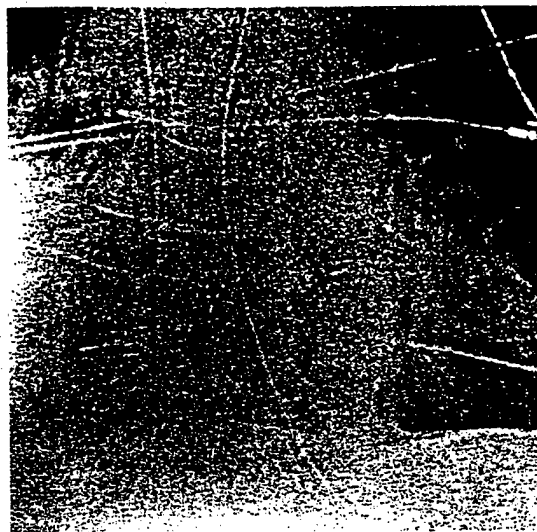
Visible noise in mediastinum with visualization of mediastinal tubes. This image shows a large amount of noise in the mediastinum. By increasing the amount of noise in the image by the use of edge enhancement, the tubes are more visible. On a standard radiograph, the radiodensity of this region of the mediastinum would be close to 0.2 optical density units. The digital system allows one to see tubes in locations where a film-screen image would show nothing, but noise will be visible on the digital enhanced image because of the low exposure in these regions (GA = 0.9, GT = F, GC = 1.2, GS = -0.05, RN = 4, RT = F, RE = 3.0).
